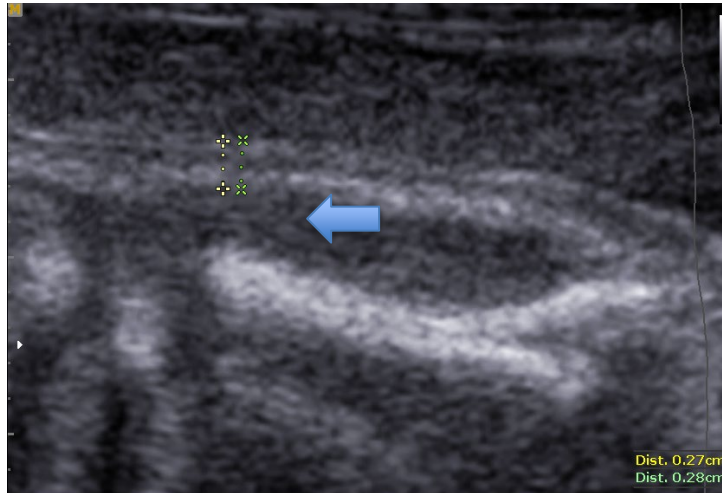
Ultrasound image of fetal subscapular fat mass (SSFM; blue arrow). Participant image used with permission.
